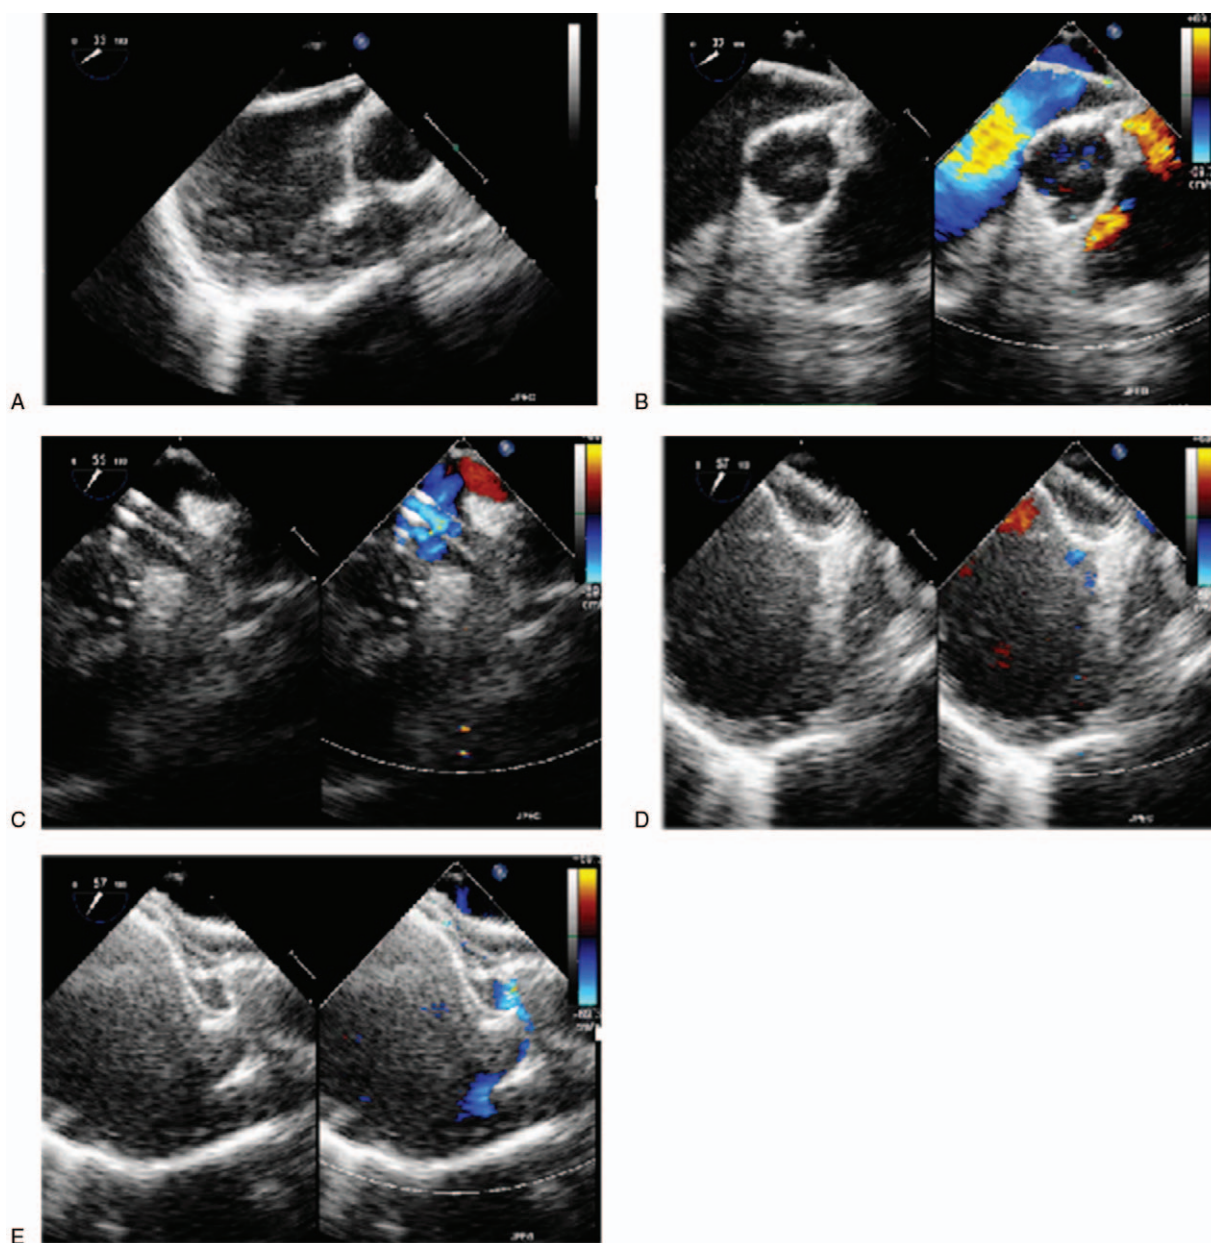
Percutaneous device closure of atrial septal defect (ASD) under the guidance of transesophageal echocardiography (TEE). A, The catheter was inserted into the right atrium via the inferior vena cava and passed into the left atrium via the atrial septal defect, under the guidance of TEE. B, The guidewire was inserted into the catheter and the catheter was inserted into the left pulmonary vein or left atrium under the guidance of TEE. C, The sheath was delivered to the left atrium under the guidance of TEE. D, The left atrial umbrella folder was expanded under the guidance of TEE. E, The right atrial umbrella folder was expanded under the guidance of TEE.
